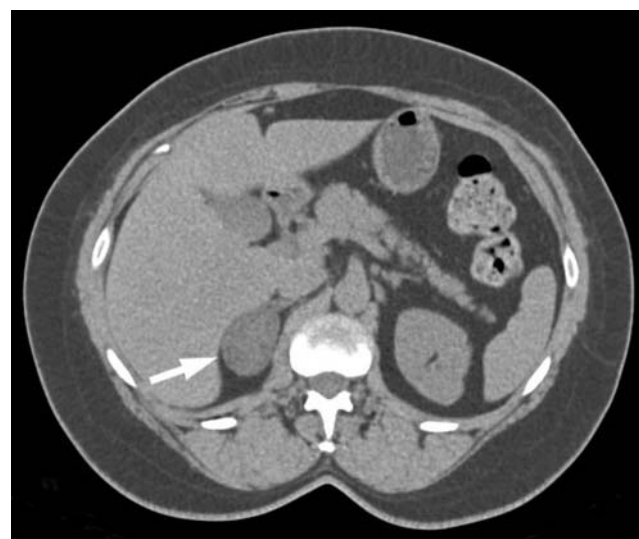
Computed tomographic scan showing a nonfunctioning cortical adenoma (arrow).
